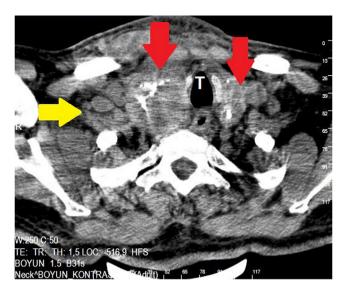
Preoperative neck CT images of the patient. The trachea is seen to be deviated to the left. Red arrow: thyroid gland featuring calcifications and extending into the retrosternal area, which cannot be clearly differentiated from the surrounding tissues. Yellow arrow: lymphadenopathies.
